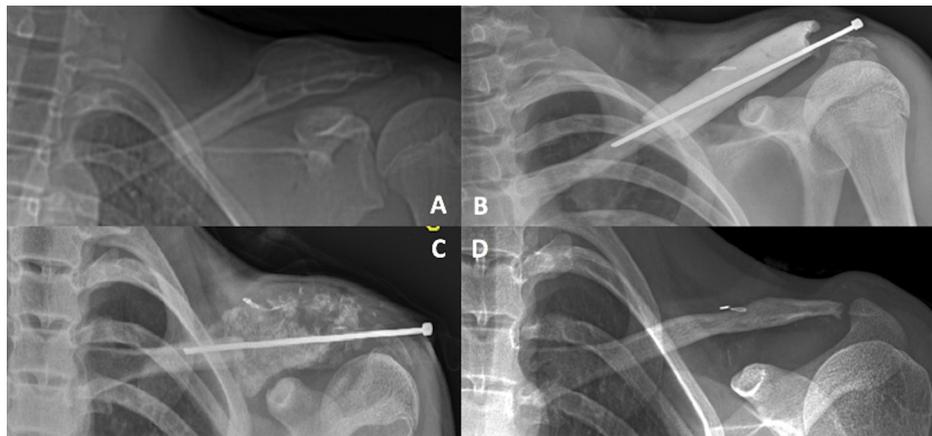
Patient #2, clavicular reconstruction for an aneurysmal bone cyst in the lateral fourth of the left clavicle. A. Pre-operative radiograph. B. Radiograph taken immediately after the first stage of the induced membrane procedure. C. Radiograph taken immediately after the second stage of the induced membrane procedure. D. Radiograph taken at last follow-up after 5.1 years, showing bone healing.
